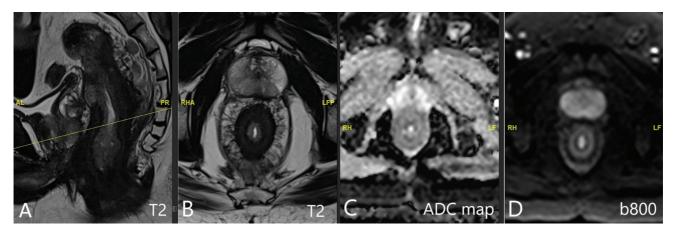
Baseline magnetic resonance imaging (MRI) of a poorly differentiated rectal adenocarcinoma patient with signet ring cells. T2 high-resolution (HR) (A) sagittal and (B) axial MRI shows a long segment annular T2 hypointense rectal wall thickening with T2 hypointense stranding within the mesorectal fat and diffuse thickening of the mesorectal fascia. (C, D) Apparent diffusion coefficient (ADC) map and high *b*-value (b-800) diffusion-weighted imaging (DWI) show no restricted diffusion. Response assessment in these cancers is challenging since residual tumor and posttreatment fibrosis cannot be effectively differentiated on T2-weighted MRI, and these rectal cancers show no diffusion restriction.
